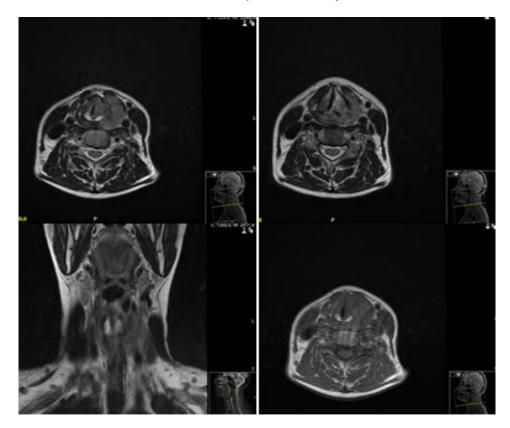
Neck MRI images with contrast. (Infraglottic, contrast enhancing mass lesion, invading left thyroid lamina and left half of cricoid cartilage, multiple lymphadenopathies, located at the inferior part of the mass, thoracic inlet and paratracheal region)
